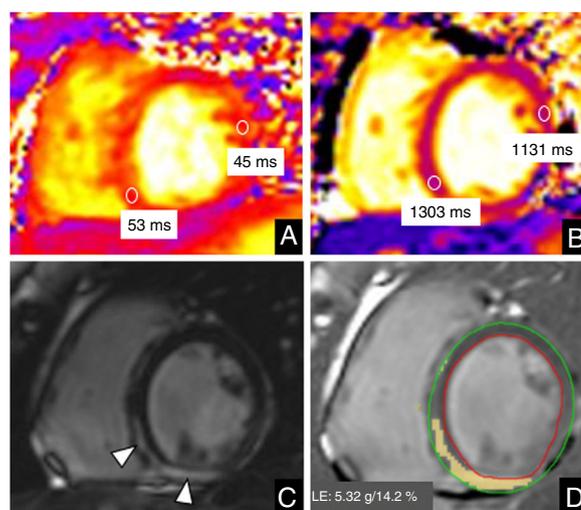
Cardiac magnetic resonance imaging in a 26-year-old woman with COVID-19 myocarditis. Mid-ventricular short axis view. A: T₂ map. B: native T₁ map. C: late gadolinium enhancement (LGE). D: quantification of late gadolinium enhancement. The study revealed slightly increased values on T₂ maps (53 ms vs 45 ms of remote myocardium) and prolonged native T₁ values (1303 ms vs 1131 ms of remote myocardium) in basal and mid-inferoseptal and inferior myocardial segments. These segments showed mesocardial and subepicardial enhancement on LGE sequences (arrowhead in C). The extent of LGE corresponded to 14.2% of the total ventricular mass.
